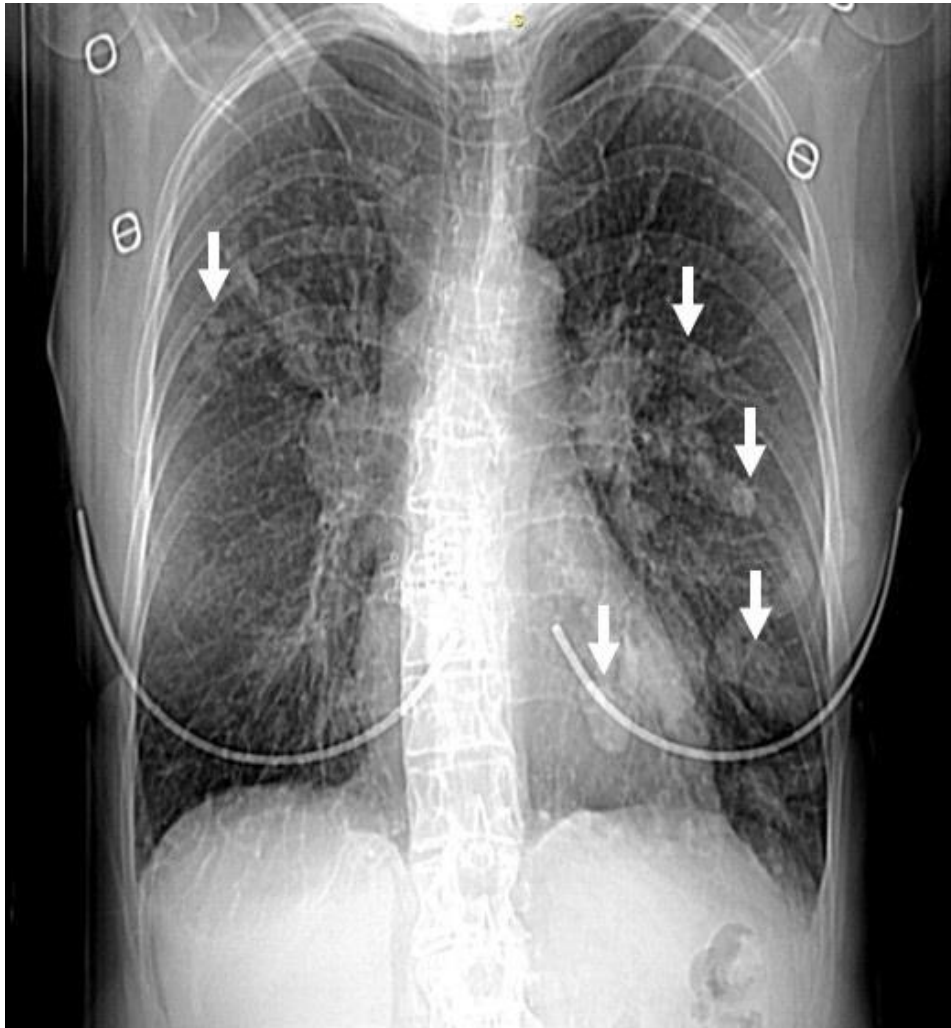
Chest radiograph with multiple pulmonary opacities (arrows).
